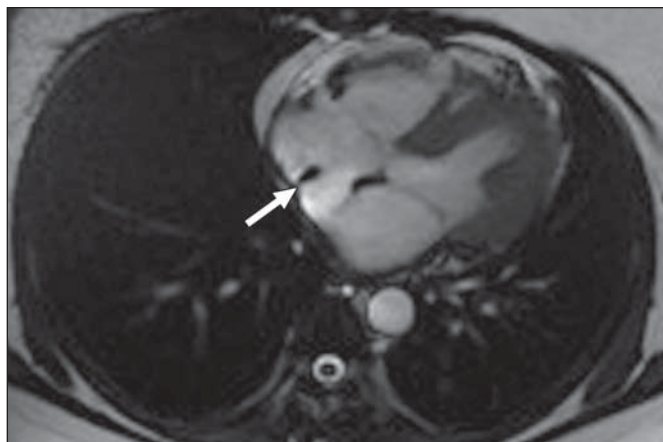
Normal cardiac MRI anatomy shown in healthy subject. Ao = aorta, AIVG = anterior interventricular groove, APM = anterior papillary muscle, AV = aortic valve, CS = coronary sinus, CT = crista terminalis, D = diaphragm, EV = eustachian valve, FO = fossa ovalis, IAS = interatrial septum, IVC = inferior vena cava, IVS = interventricular septum, LA = left atrium, LAAP = left atrial appendage, LAD = left anterior descending artery, LCA = left coronary artery, LCCA = left common carotid artery, LCX = left circumflex artery, LIV = left innominate vein, LMB = left mainstem bronchus, LPA = left pulmonary artery, LV = left ventricle, LVOT = left ventricular outflow tract, MB = moderator band, MV = mitral valve, PA = pulmonary artery, PMVL = posterior mitral valve leaflet, PPM = posterior papillary muscle, PUV = pulmonary valve, RA = right atrium, RAAP = right atrial appendage, RCA = right coronary artery, RMB = right mainstem bronchus, RPA = right pulmonary artery, RV = right ventricle, RVOT = right ventricular outflow tract, SVC = superior vena cava, T = trachea, TV = tricuspid valve, PV = pulmonary vein.
